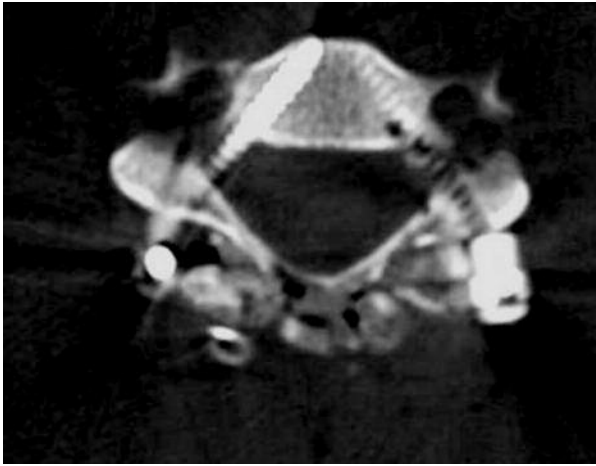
Postoperative CT scan demonstrating accurate pedicle screw placement in the right pedicle of C5, and grade 1B pedicle screw malposition in the left side of C5 pedicle.
